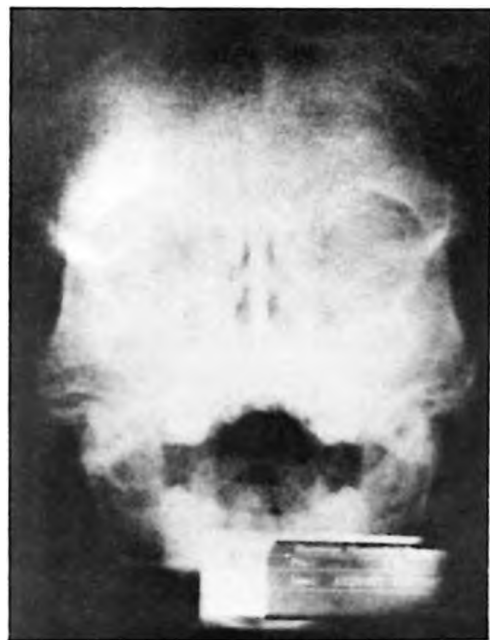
Waters radiograph of Case 2 showing no pneumatization in paranasal sinuses and coarse trabeculation of maxilla and mandibula.
